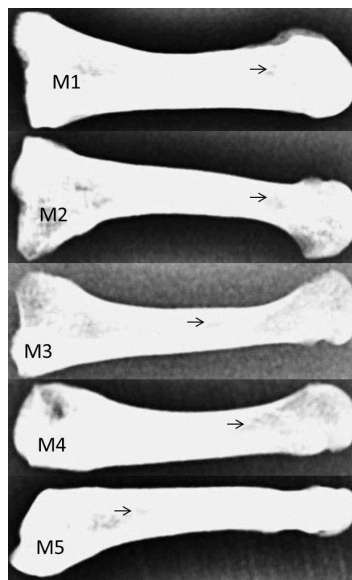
The radiographic film showing metatarsals and their nutrient foramina (arrow mark).
